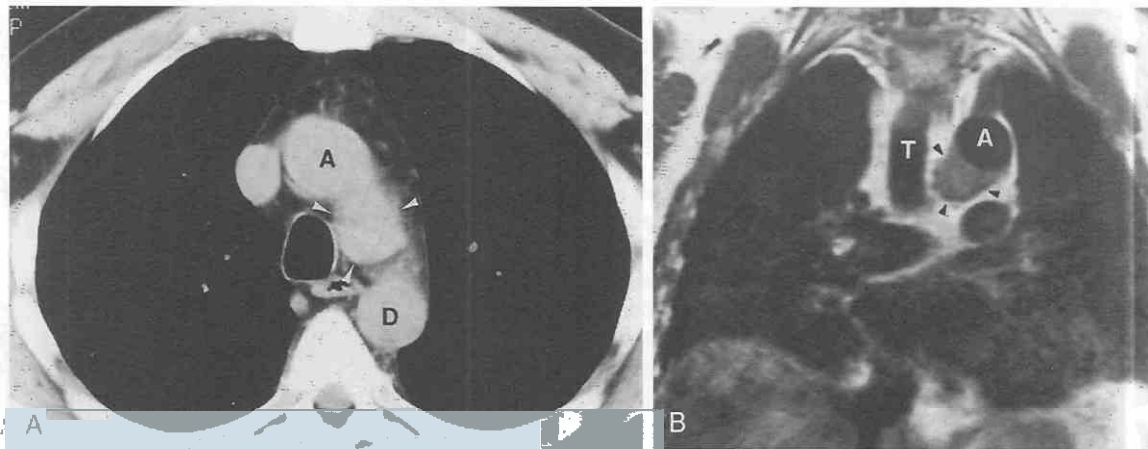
Paraganglioma. A, CT shows homogeneous soft tissue mass in aortopulmonary window (arrowheads). The mass is difficult to distinguish from the aorta. A, ascending aorta; D, descending aorta. B, Coronal T1-weighted MR image shows intermediate-signal-intensity aortopulmonary window mass (arrowheads). Biopsy revealed paraganglioma. A, aorta; T, trachea.
